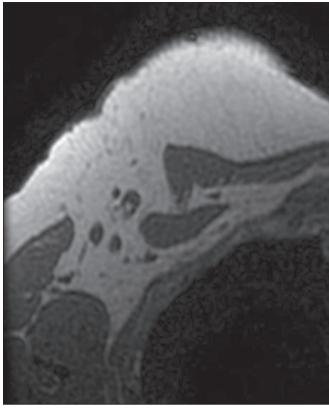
A 70-year-old patient with a 15-mm invasive ductal carcinoma that was positive for estrogen and progesterone receptors. T1-weighted MRI sequences without fat suppression, showing lymph nodes that were classified as positive. In a dissected ipsilateral lymph node, 4-mm macrometastases were detected, providing an example of a true-positive case.
